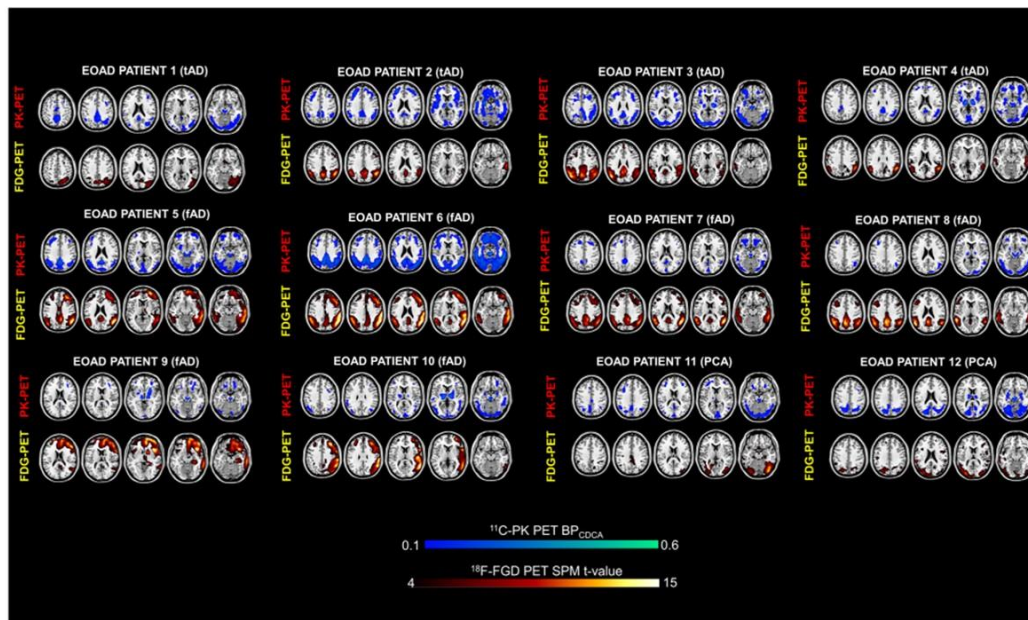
Single-subject maps of [^{18}F]FDG-PET brain hypometabolism and [^{11}C]PK11195-PET TSPO overexpression (source: Tondo *et al.*, 2020b).
